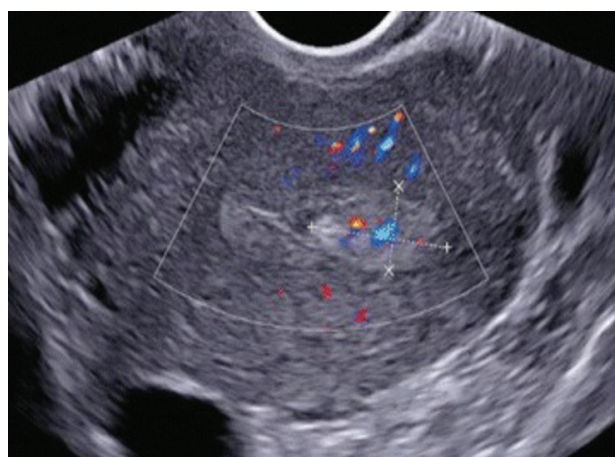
Doppler ultrasound: solid, hyperechogenic, homogeneous endometrial polyp with vascular pedicle.<sup>16</sup>
